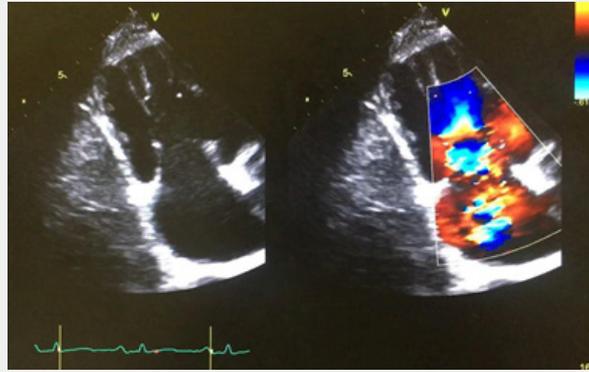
Transthoracic echocardiography apical view focused on right chambers showing thickened and retracted tricuspid valve with severe regurgitation and coaptation gap.
